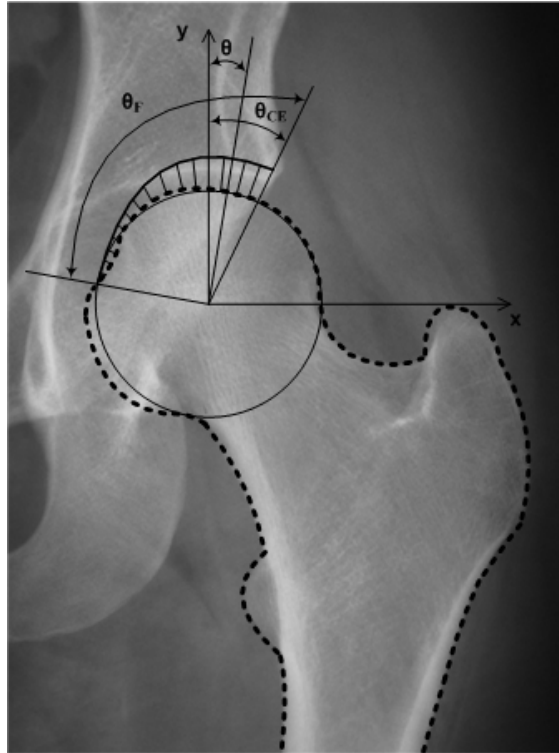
Radiographic image utilized for modeling the healthy femur together with the load distribution and angles according to Brinckmann 2002, Nordin & Frankel 2001, Van Rietbergen 2003. The dashed line indicates the femur's contour drawn extrapolated for the FE analysis.
